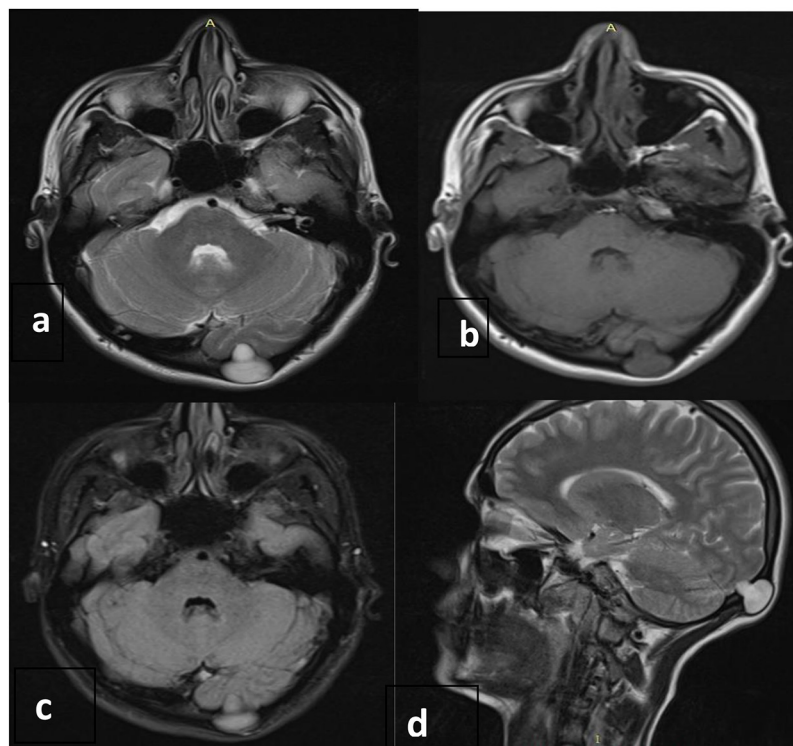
(a) T2WI shows lobulated lesion in the occipital region slightly left of the midline. (b) T1WI shows lesion is isointense to brain parenchyma. (c) DWI shows presence of restricted diffusion within the lesion, suggestive of epidermoid. (d) Sagittal T2DWI again showing lobulated lesion involving both the inner and outer table of the calvarium.
